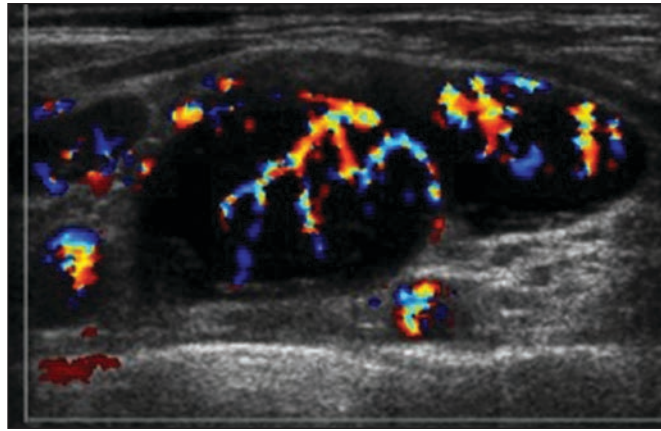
74-year-old man with metastatic thigh lymphoma. Example of difficulty differentiating hematoma from hemorrhagic soft-tissue mass with ultrasound.
